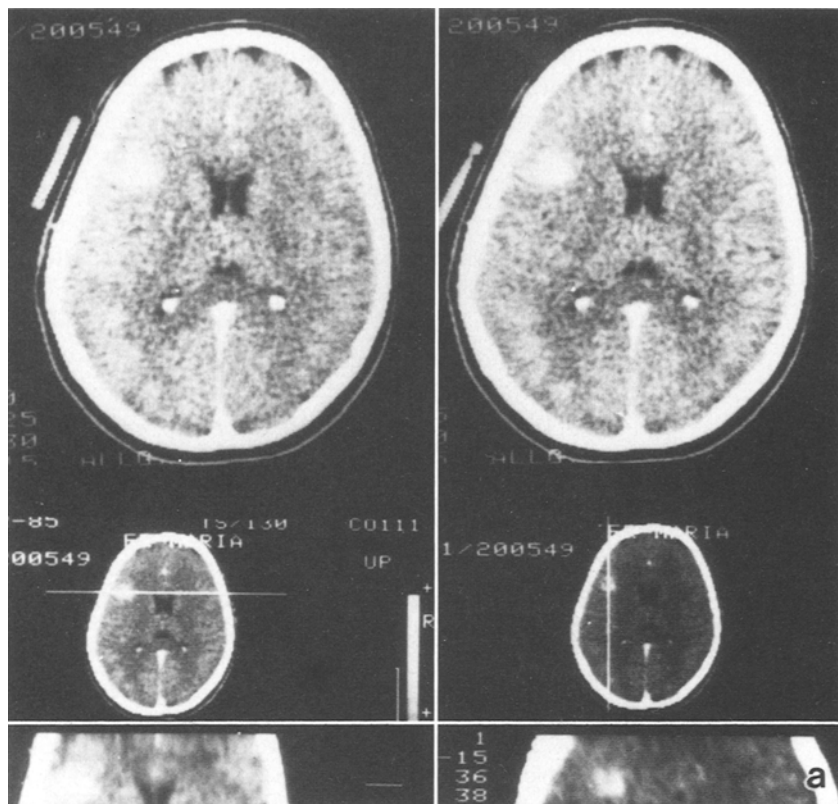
Cavernoma below the Broca region (M. J. 200549/54) (a) and below Broca and central convolution (S. T. 110477/85) (b), exact localization by CT with marking (a) and MRI (b). Intersylvic, integral persulcal approach and removal with CUSA in both cases. Normal course. No signs 6 months, 5 months respectively
